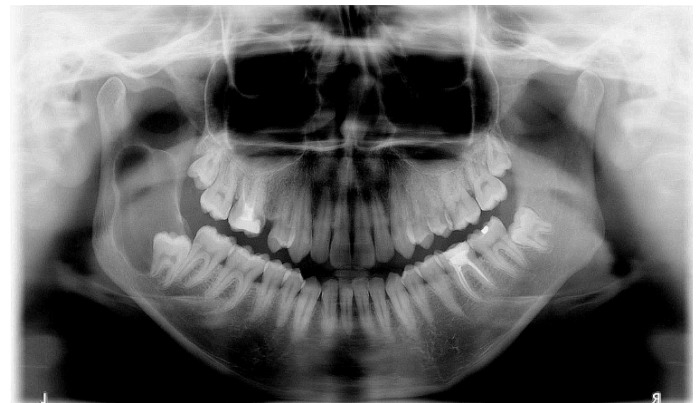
Preoperative panoramic radiograph showing a large unilocular radiolucent lesion with relatively well-circumscribed margins.
